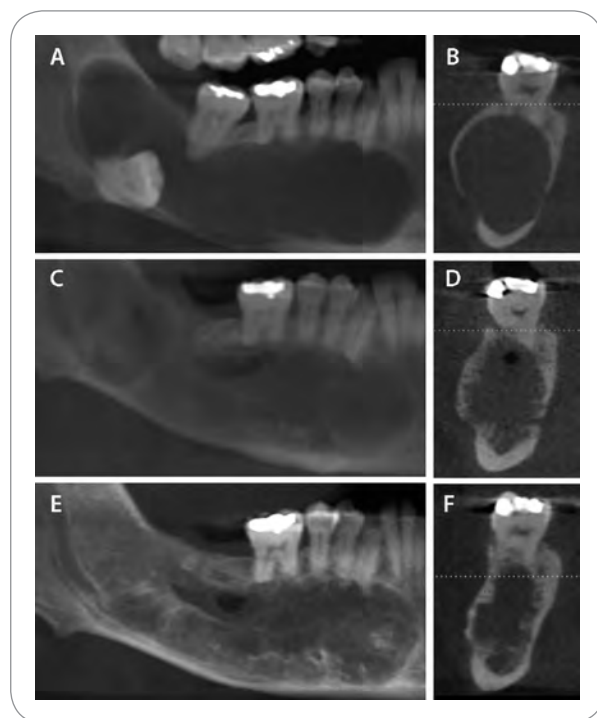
Follow-up of a keratocystic odontogenic tumor (OKC). Data acquired using an iCAT CBCT machine. Images are reformatted in iCATVision software. (A) Presurgical scan showing a large lesion in the right mandibular body and inferior displacement of the third molar. (B) Presurgical coronal view through the first molar area shows significant buccal expansion and localized thinning. (C) and (D) are eight months postsurgical. (C) Second and third molars were removed and lesion was marsupialized. (D) Eight-month postsurgical coronal view through the first molar area shows lesser expansion of the buccal cortical plate compared to the presurgical view. Note new bone formation on the inner aspect of the cortical plates. (E) and (F) are 20 months postsurgical. (E) The cavity has increased density, indicating almost uniform osseous healing. The surgical window is visible distal and inferior to the first molar. (F) Twenty-month postsurgical coronal view through the first molar area shows substantial reduction in the buccal expansion of the lesion. The cortical bones are thicker compared to that on the presurgical scan.
